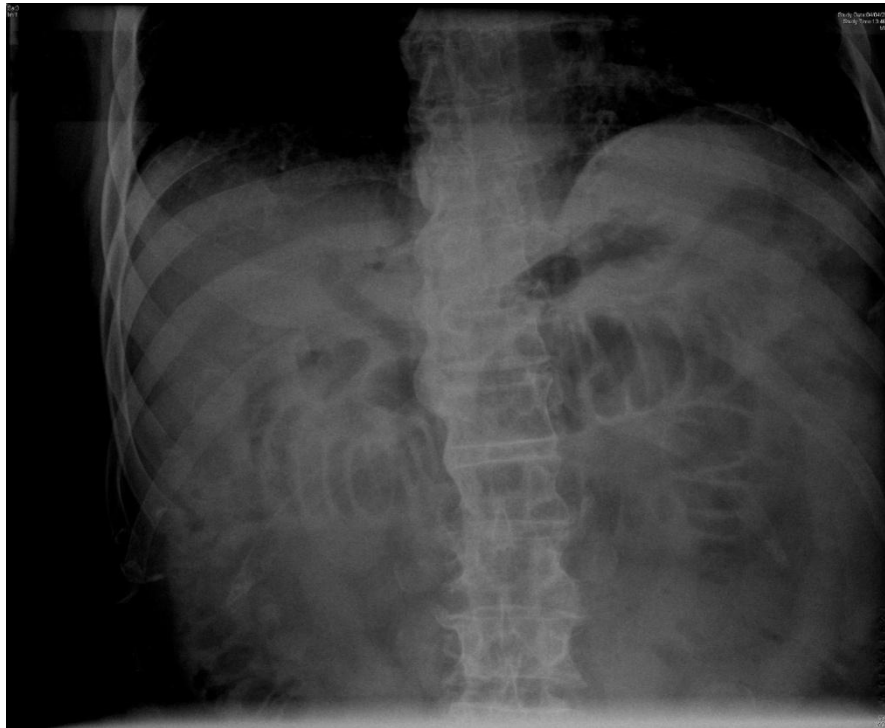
Xray showing dilated small bowel loops.
